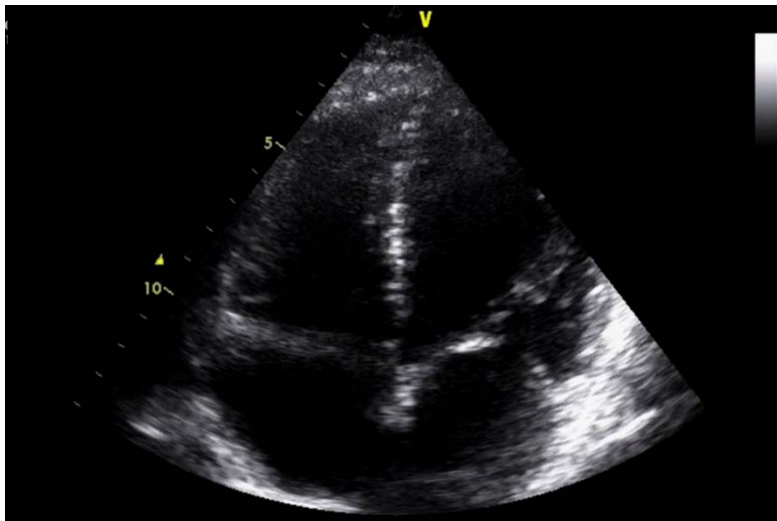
Still image of a bubble-free heart visible during two-dimensional ultrasonic monitoring following a conservative dive profile (see Figure 3).
